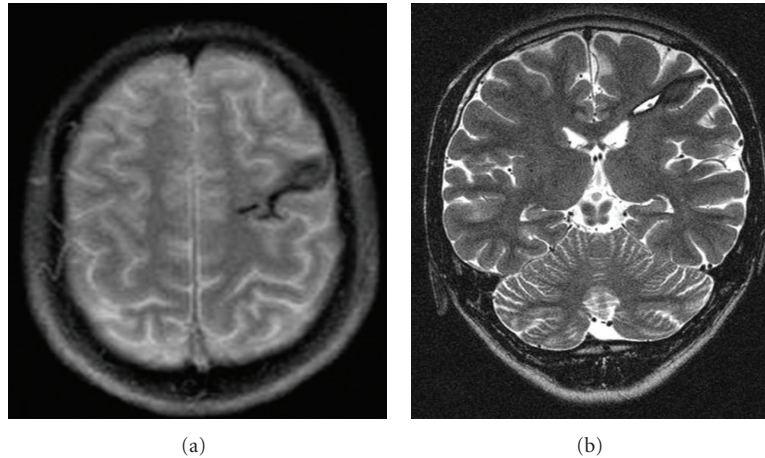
A 17-year-old boy was presented with seizures one month after a prior head injury. Axial T1-weighted image (a) and coronal T2-weighted image (b) showed the hemosiderin deposition and a small CSF-filled cavity of the left middle frontal gyrus.
